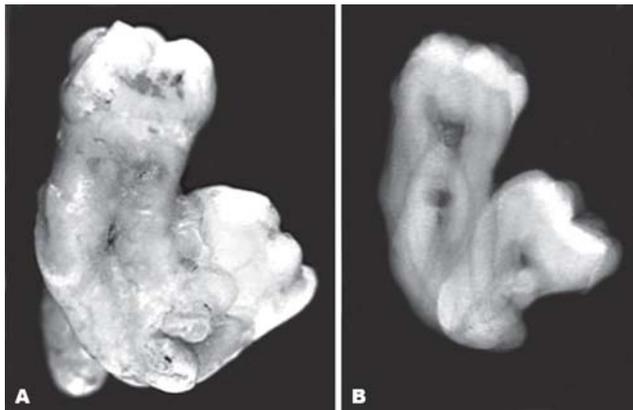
showing: - A. Slide view of concrescence using CBCT. B. Conventional X- ray view of concrescence.
